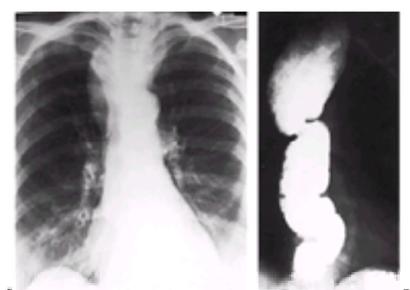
Achalasia presenting as a superioposterior mediastinal mass. Posteroanterior chest roentgenogram (A) and barium contrast study (B) demonstrate the megaesophagus.
